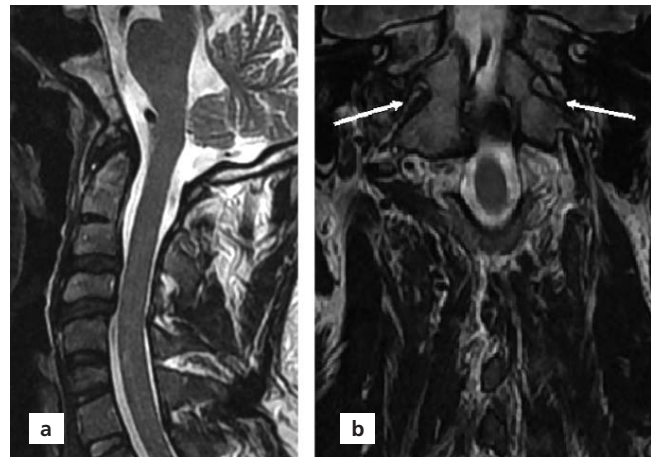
(a) 44-year-old woman with AOA. Fusion of the anterior arch of atlas with occipital condyle, C2–3 vertebrae fusion and suboccipital muscle atrophy were observed on sagittal T2-weighted MR image. (b) Coronal T2-weighted image shows bilateral fusion of lateral bodies (arrows) with occipital condyle. Vertebral arteries passing through a bony channel were also observed.
